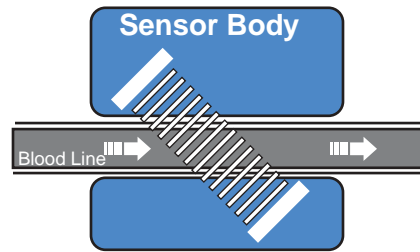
Blood line inserted into the groove of the flow/dilution sensor body. Direction of flow is indicated by arrows. Ultrasound beam is shown emanating from one of four transducers in the sensor body.
